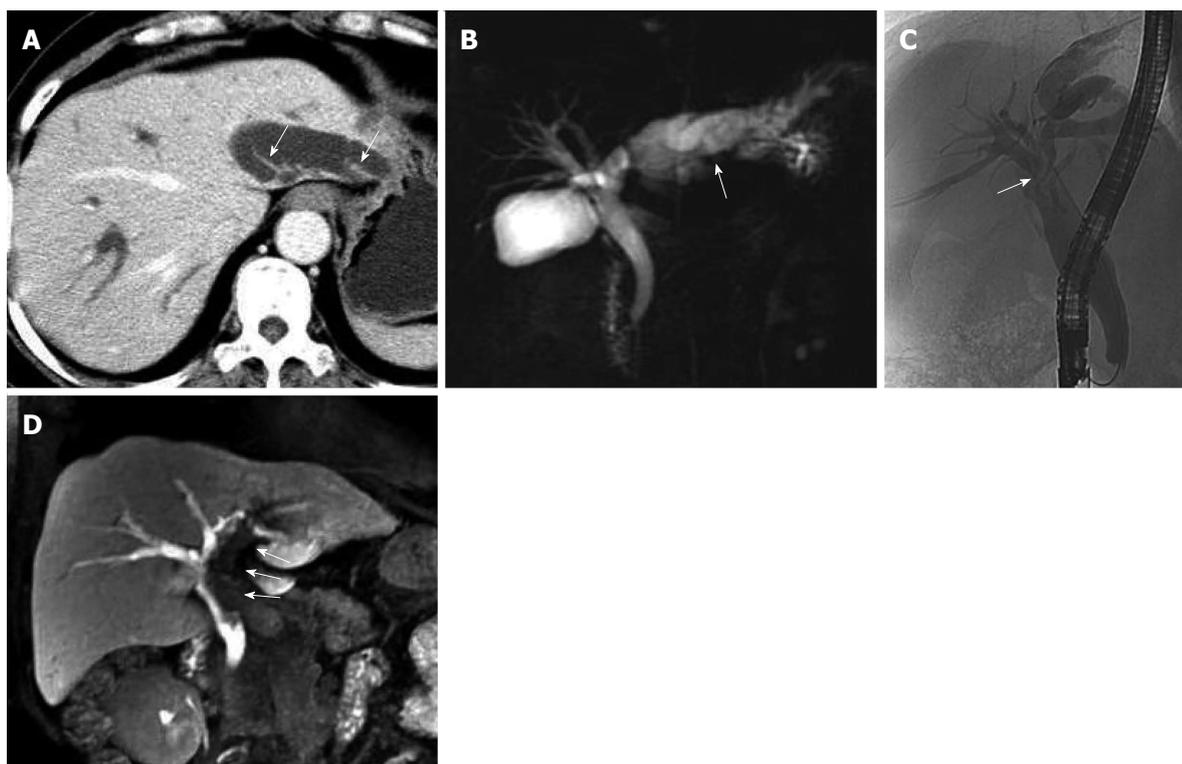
Fifty-nine-year-old female patient with intraductal papillary mucinous neoplasm of the bile duct (case 1). A: Axial contrast-enhanced computed tomography in the portal phase; B: Magnetic resonance cholangiopancreatography showed extensive intra- and extrahepatic bile duct dilatation and multiple hydra-like protrusions (arrows) in the markedly dilated left intrahepatic bile duct (arrow); C: Endoscopic retrograde cholangiopancreatography showed extensive intra- and extrahepatic bile duct dilatation, particularly in the left intrahepatic and common bile ducts. Bile ducts in the liver hilar appeared more transparent due to the local aggregation of mucin (arrow); D: Multiple planar reconstruction of gadolinium-ethoxybenzyl-diethylenetriamine-pentaacetic acid-enhanced magnetic resonance imaging in the hepatobiliary phase showed dilatation of the bile duct and filling defects in the left intrahepatic and common bile ducts, with a cup-shaped contrast filling edge (arrows). The filling defects were caused by mucus retention, which was confirmed by endoscopy.
